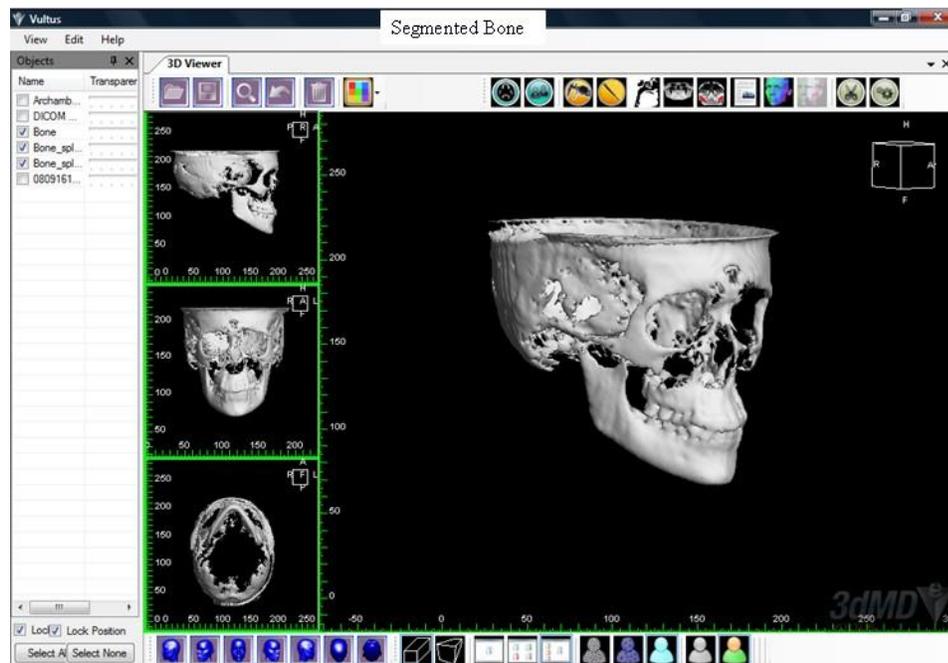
Bone image from cone beam radiograph
